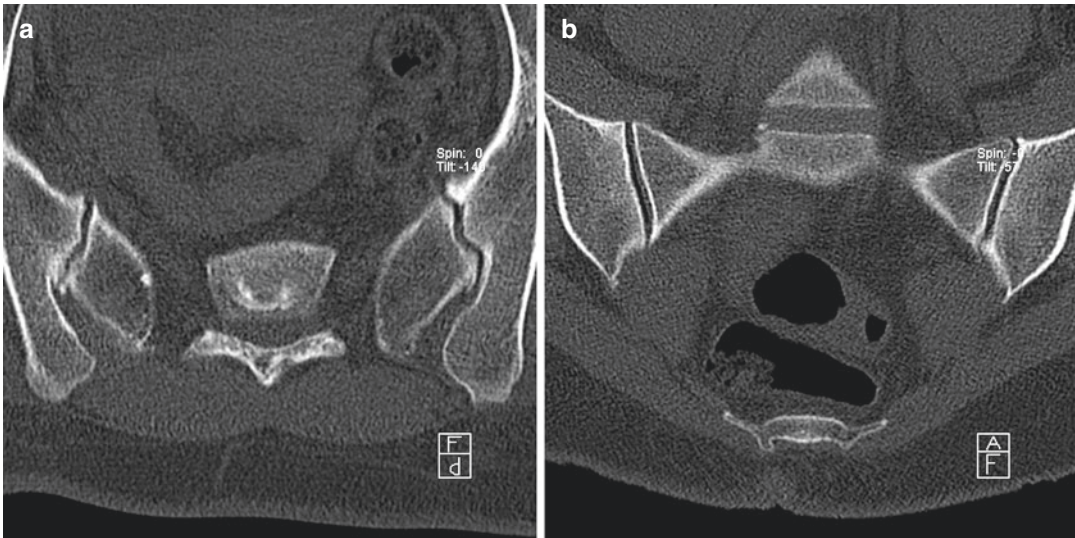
(a, b) 49-year-old male with SIJs osteoarthritis. (a) axial and (b) coronal CT images show bilateral vacuum phenomenon, mild subchondral sclerosis and anterior marginal osteophytosis, with subtle cortical irregularity
